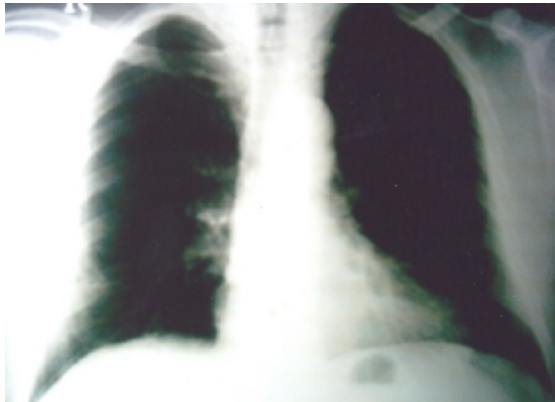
Normal chest radiograph before operation.
